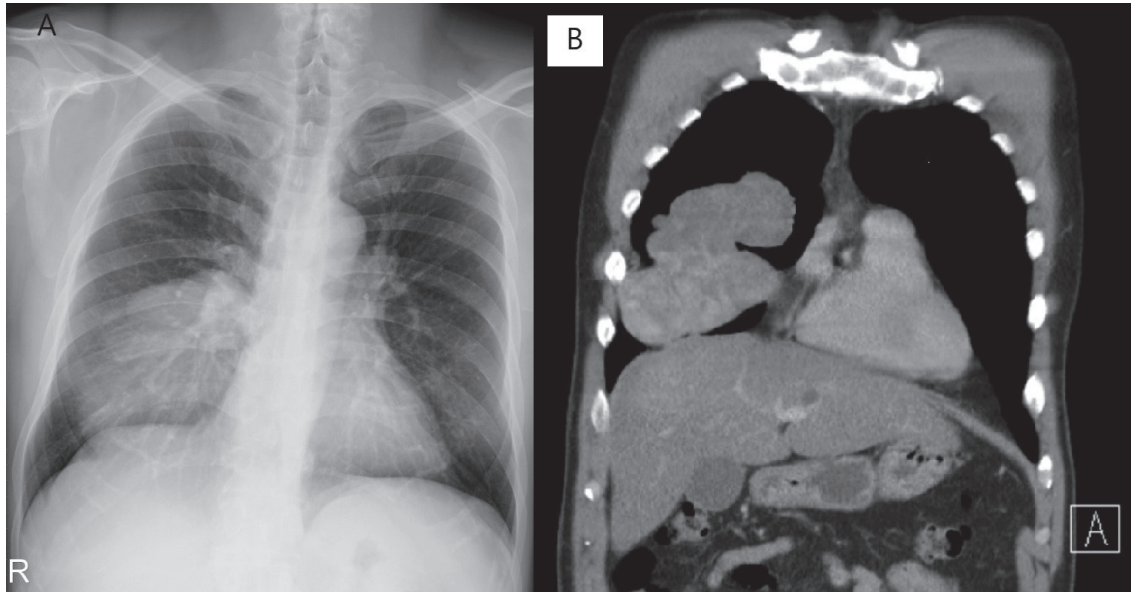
(A) Initial chest radiography showed right lower lung field consolidation. (B) A chest computed tomography coronal view revealed a huge lobulated mass with right middle lobe and right chest wall involvement.
